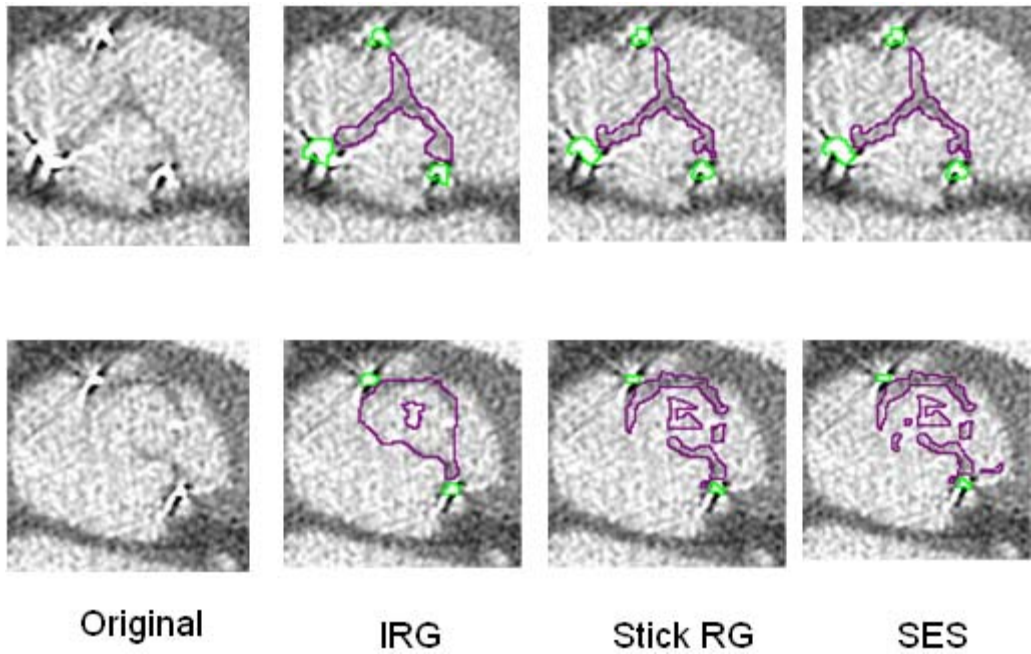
Examples of segmented CT-Slices obtained in case 3 - BOU: metallic stent, calcifications and leaflets are indicated by green, brown and purple border respectively.
